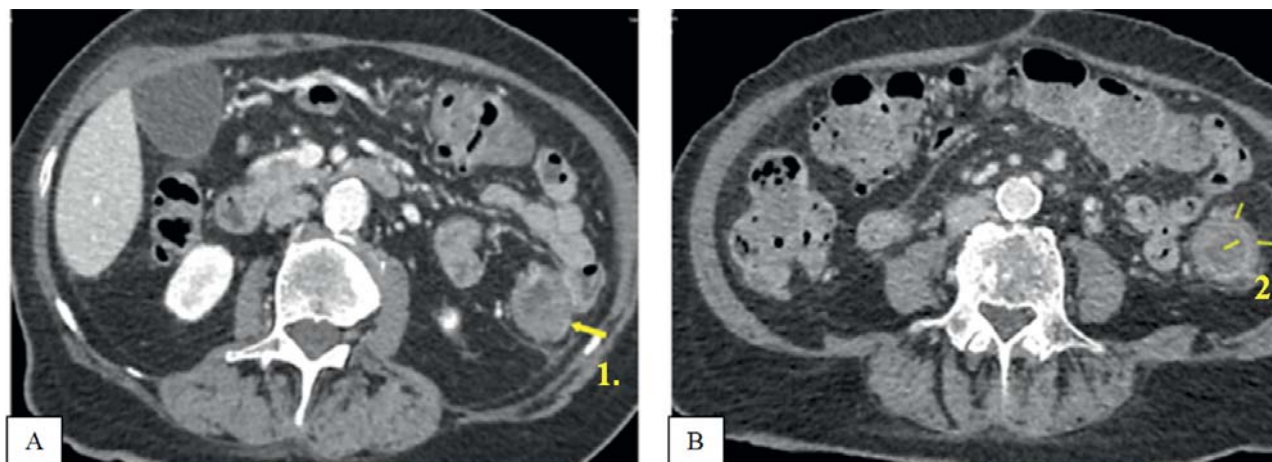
Abdominal CT: mild exudation along the descendent colon was determined. Multiple diverticula of all parts of the large intestine up to 10 mm in size were noted. There was increase density and edema
